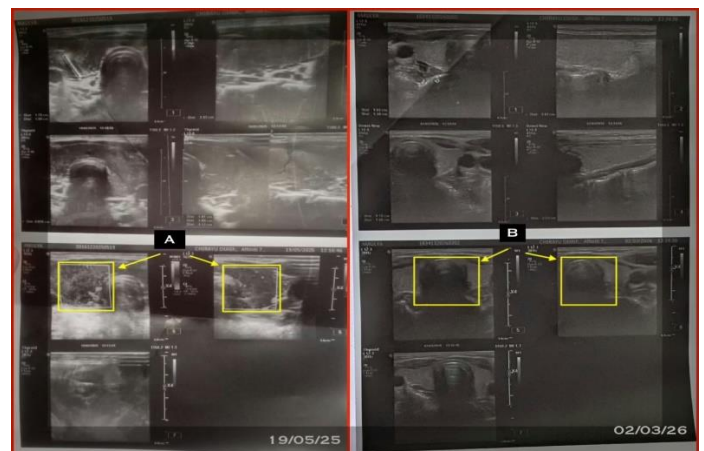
Comparative thyroid ultrasonography images showing baseline (A) and follow-up (B).
